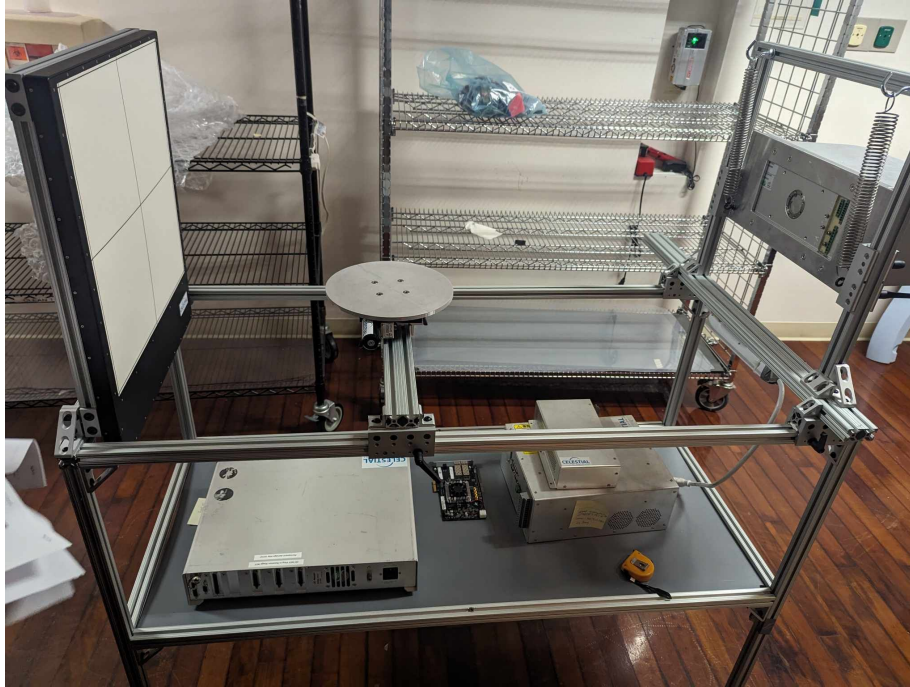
Initial conception of the benchtop CBCT system, inherited detector, deprecated X-ray source-controller and rotary stage, stage controller, and arduino microcontroller.
